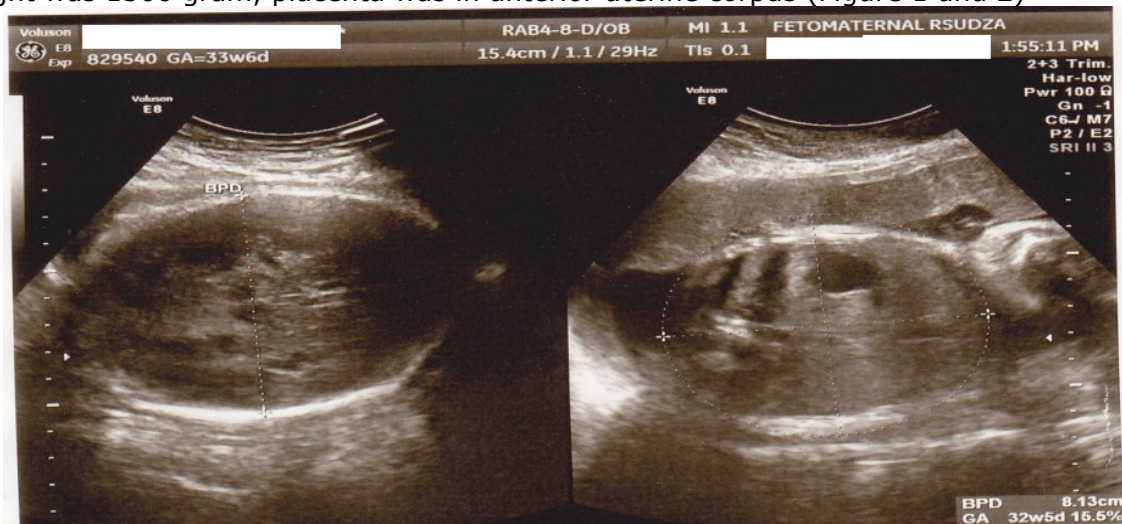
The ultrasound finding showed the elevated ratio of head circumference to abdominal circumference 1.25 ( $>1$ ) which was typical of suspected growth retarded fetus
